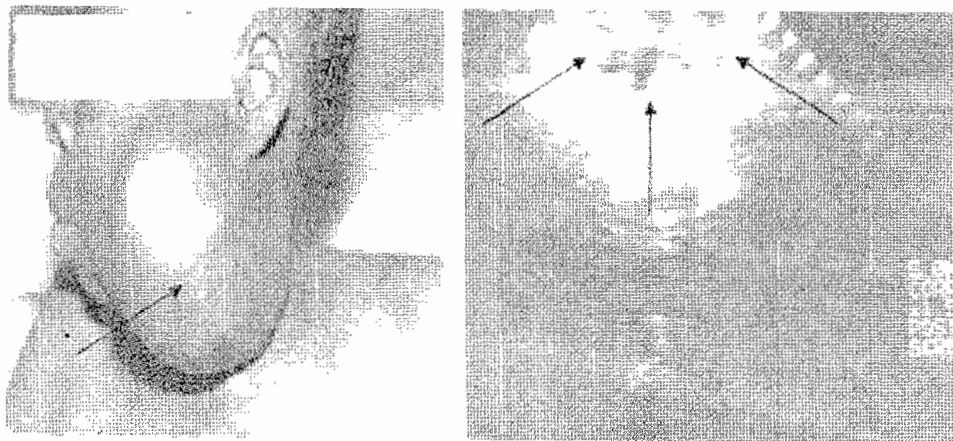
Clinical and ultrasonographic feature of a parotid mass
